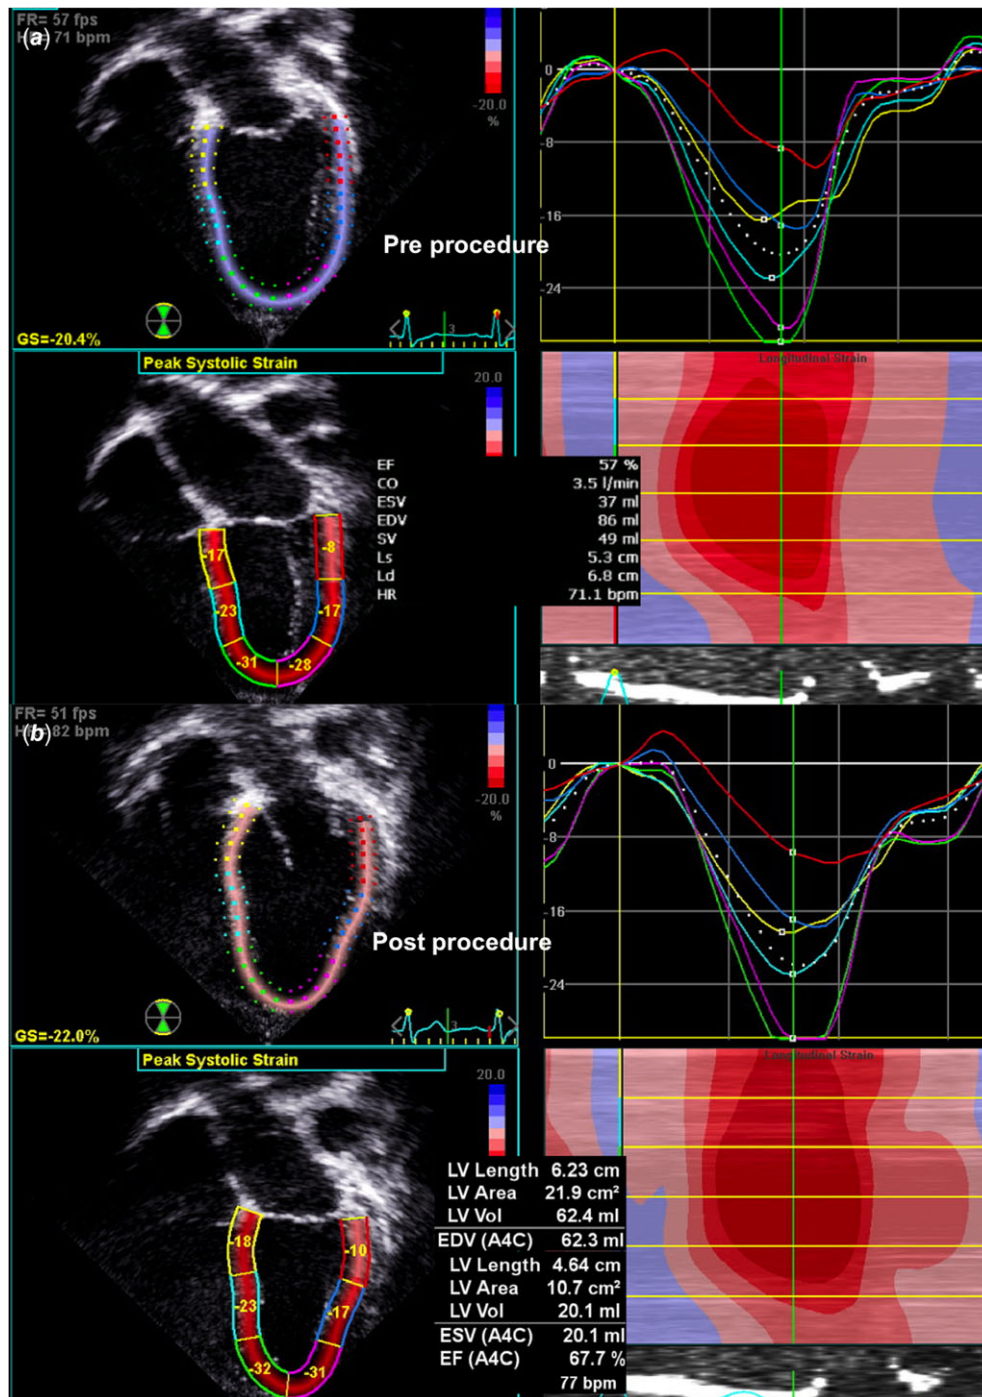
Before the intervention (a), the left ventricle was mildly dilated on a four-chamber echocardiographic view with basal lateral hypokinesia and the ejection fraction was 57% and longitudinal strain was -20% . After the intervention (b), there was a reduction in the left ventricular volumes along with improvement of ejection fraction to 68% and longitudinal strain to -22% .
